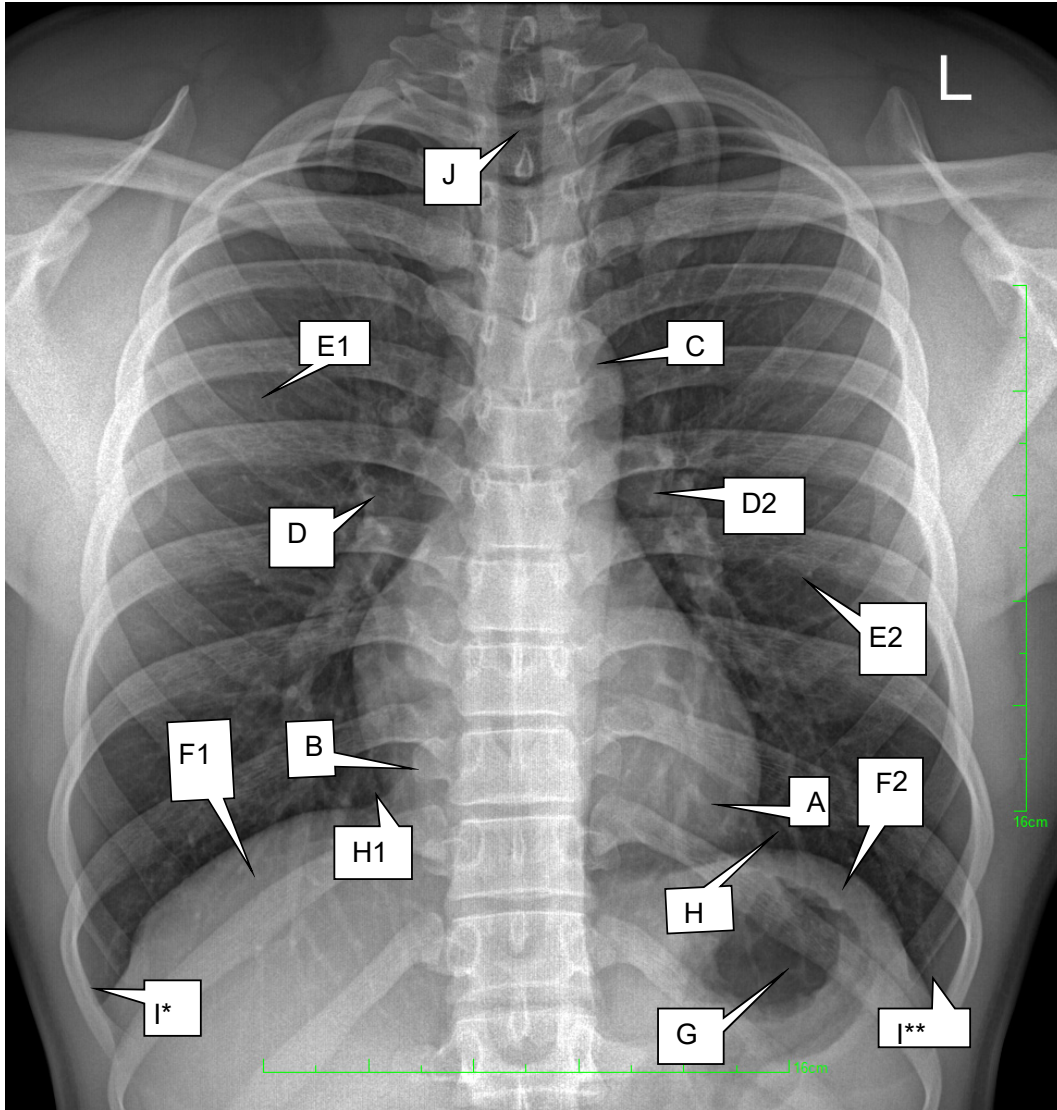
This is a posterior-anterior radiograph of the chest of an adult male.
